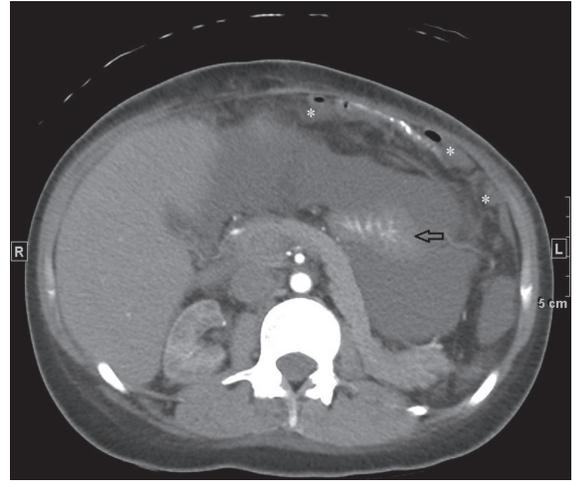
Computed tomography image of abdomen with oral and intravenous contrast. Asterisks mark thickened peritoneal membrane with nodularities. Thickened bowel wall is surrounded by encapsulated ascitic fluid (arrow).
